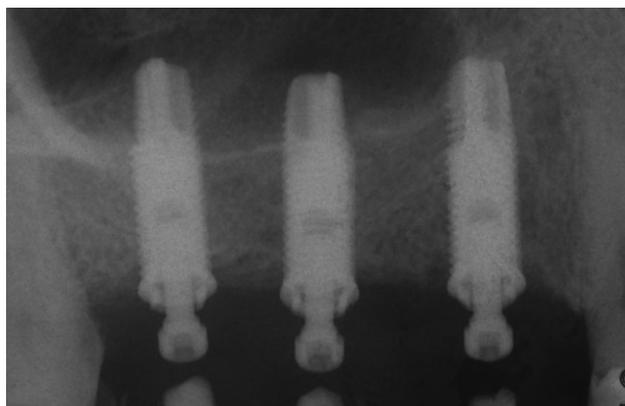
Intraoral X-ray performed after 6 months of loading.
